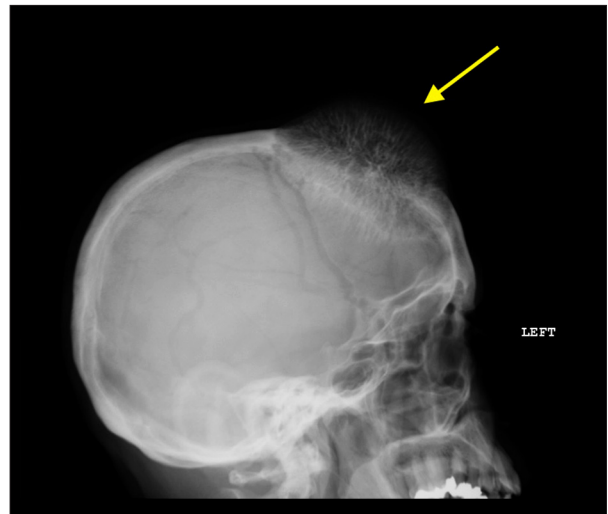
Lateral view skull x-ray demonstrates an expansile lesion with a sunburst pattern arising from the frontal skull (yellow arrow).
